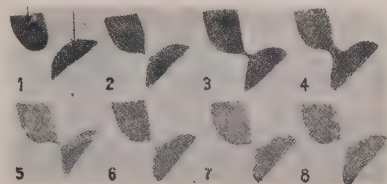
Plates of the passage of food through the cardia as depicted in serial roentgenograms. (From Palugyay.)
